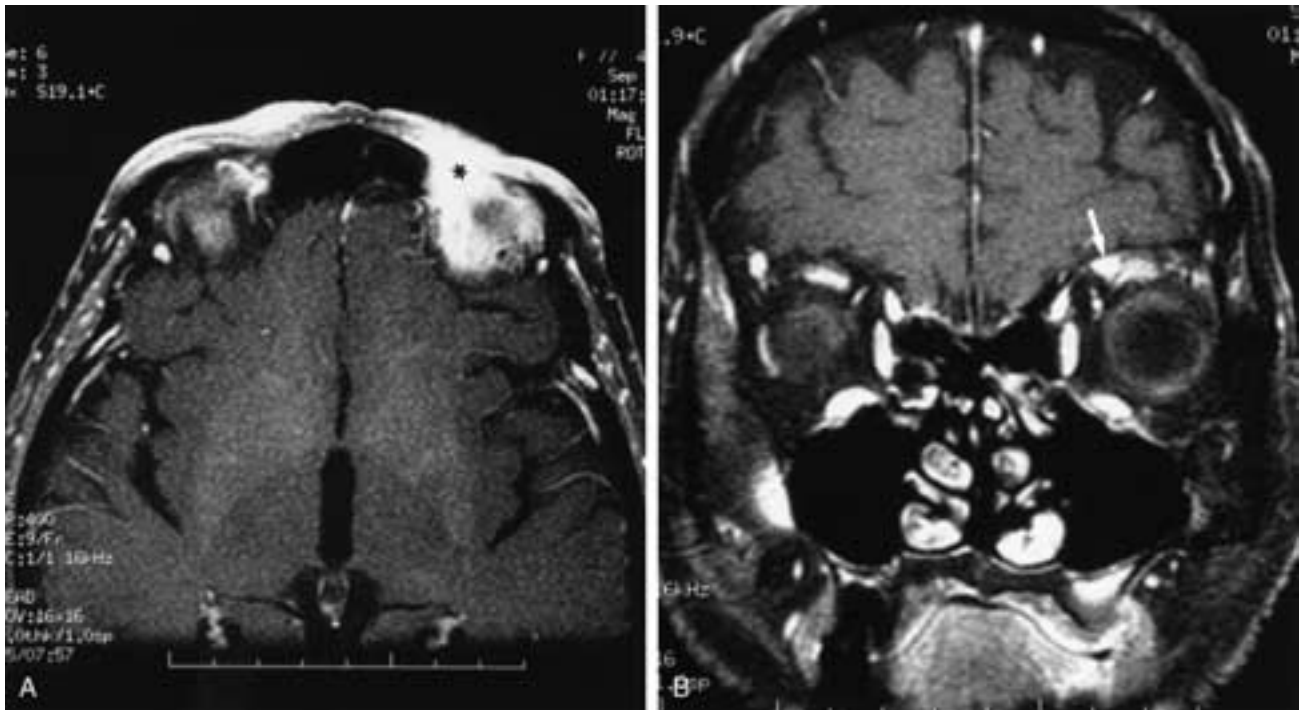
Squamous cell carcinoma in the left medial supraorbital region with PNS along the supratrochlear branch of the ophthalmic nerve. A, Contrast-enhanced axial T1-weighted MR image with fat suppression shows enhancing tumor in the left supraorbital region (asterisk). B, Contrast-enhanced coronal T1-weighted MR image with fat suppression shows thickening and abnormal enhancement of the supratrochlear branch of the ophthalmic nerve (arrow) just medial to the normally enhancing superior muscle complex.
